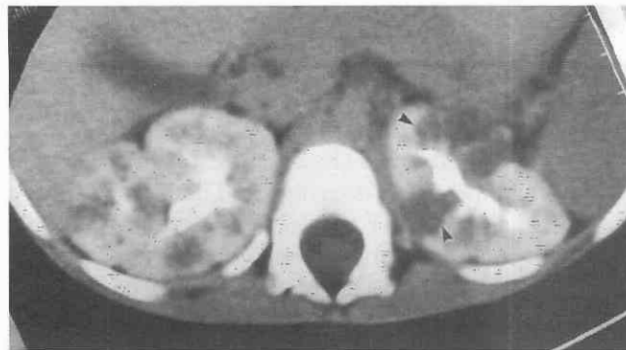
Autosomal recessive polycystic kidney disease in a 30-month-old infant with normal renal function. A contrast-enhanced CT scan shows dilated collecting ducts in the renal medulla (striated nephrogram) bilaterally and relative preservation of the renal cortex. Occasional macroscopic cysts (arrowheads) are present in the left kidney.
